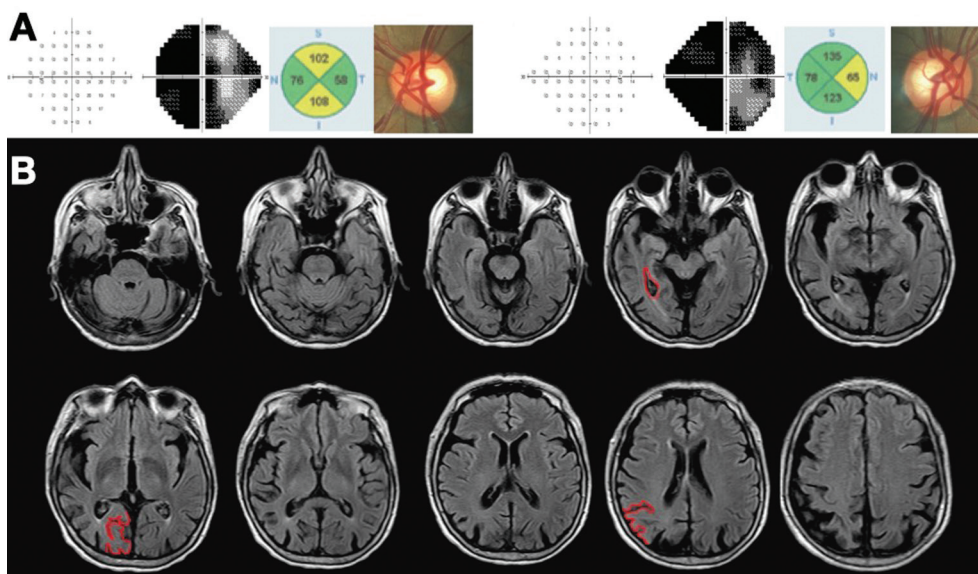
Patient's current tests A: Visual fields showing a left homonymous hemianopia, while the optic nerve resulted within normal limits measured with ocular coherence tomography: optic nerve photography is included on the right corner for each eye; B: Magnetic resonance imaging, showing marked atrophy on occipital lobes with no other pathologic findings, more prominent on the right side (marked in red). Also, lateral ventricular enlargement was noticed. With these findings, posterior cortical syndrome was diagnosed.
